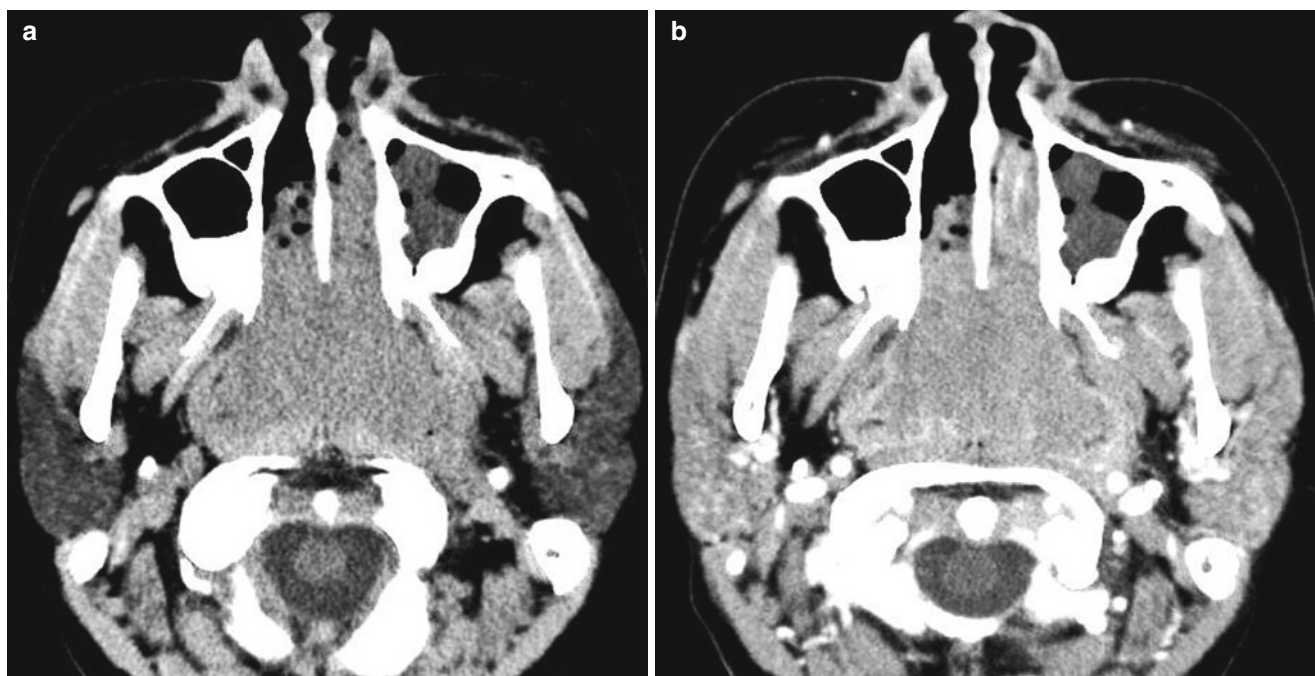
Burkitt lymphoma in a 12-year-old boy. (a) Nonenhanced CT scan shows an isoattenuated mass relative to the muscle involving both nasal cavities and entire nasopharynx. (b) Contrast-enhanced CT shows homogeneously enhancing mass
